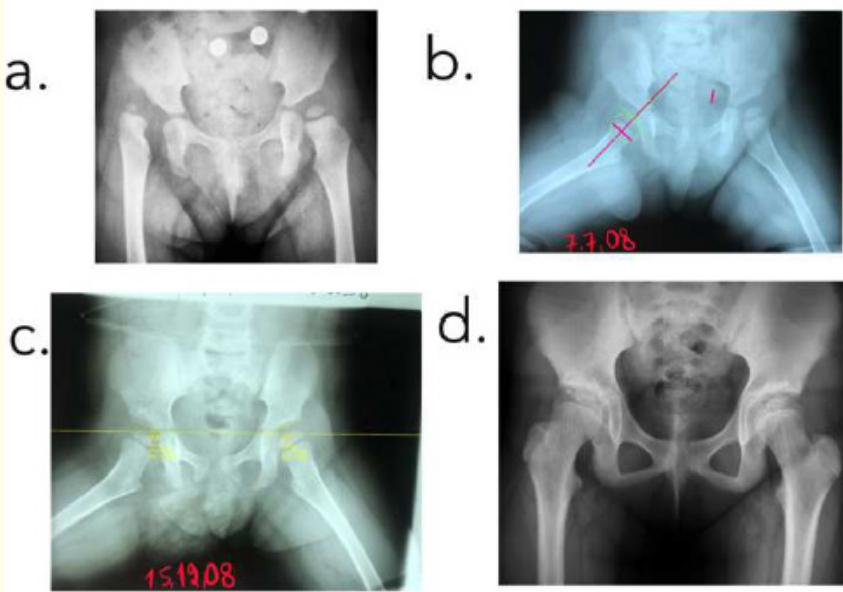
a. Initial Anteroposterior radiograph of the pelvis of a 30 month-old girl with unilateral Tönnis grade-III hip dislocation. b. Starting phase B with abduction splint. Entry angle is zero on X-ray. c. Anteroposterior radiograph 5 months later, Acetabular Index now 25 degrees showing that the acetabulum has remodeled quickly. d. Anteroposterior radiograph, at 10 years of age. Complete recovery.
